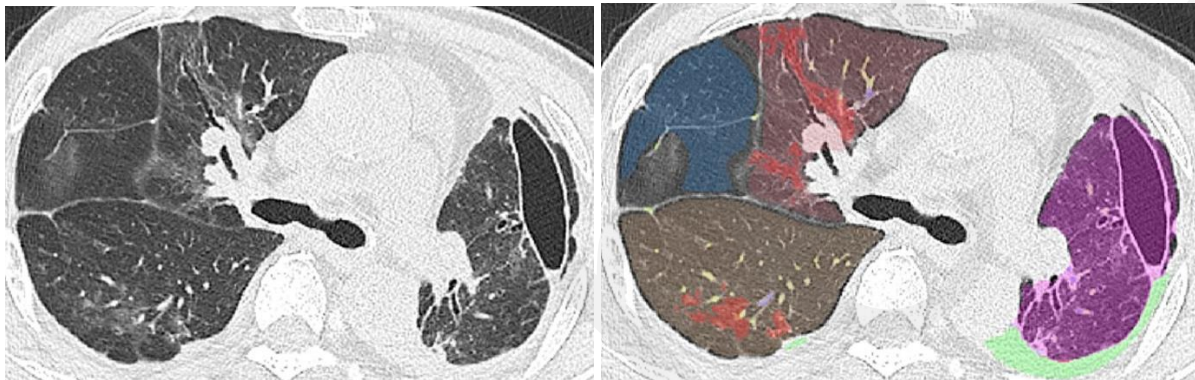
Chest CT from a 66-year-old woman with the Delta variant of COVID-19 with a typical CT appearance.
